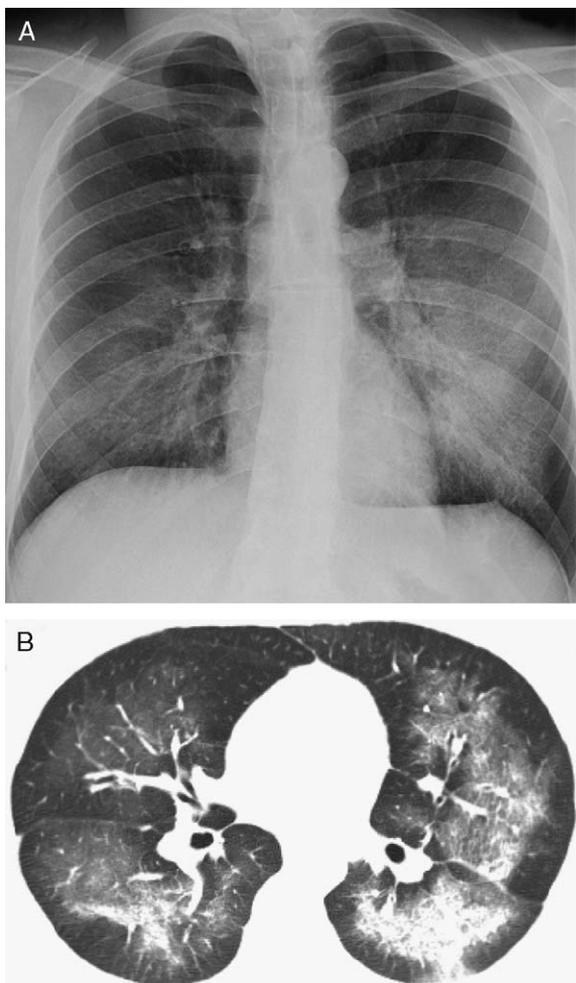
A 34-year-old man with pulmonary edema due to crack cocaine. A, Posteroanterior chest radiograph shows faint, bilateral peri-hilar opacities. B, High-resolution CT image shows symmetric bilateral ground-glass opacities with relative sparing of the subpleural regions. Areas of consolidation are present in the dependent lung regions.
